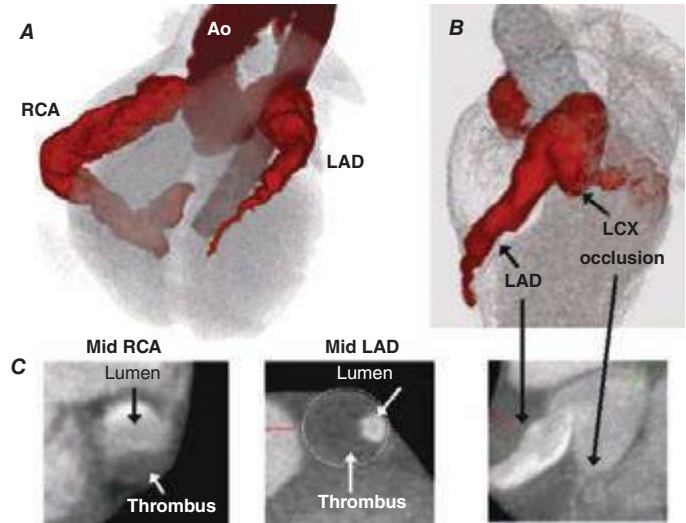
9 Coronary computed tomography angiography (CTA) obtained from a 13-year-old boy with a history of Kawasaki disease who presented with limited exercise capacity and occasional, atypical chest pain. A, B, Three-dimensional cardiac CT image reconstruction demonstrating large three-vessel coronary artery diffuse aneurysms with proximal, nondominant left circumflex (LCX) artery occlusion. C, Two-dimensional contrast-enhanced coronary CTA demonstrating mid-RCA and mid-LAD thrombi that are nonocclusive layered and near circumferential thrombi, respectively, and proximal LCX occlusion. Ao, aorta; CT, computed tomography; LAD, left anterior descending; RCA, right coronary artery.
